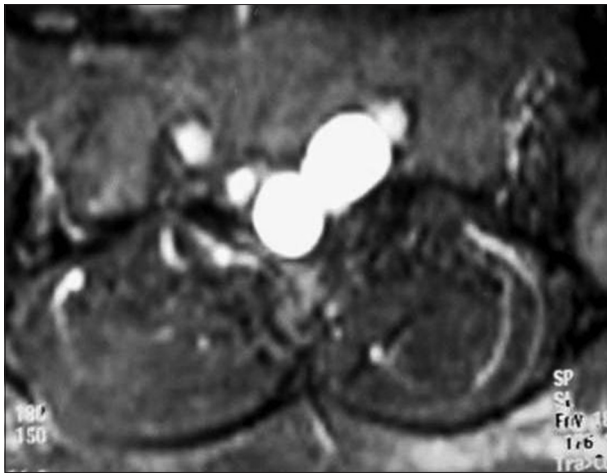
Magnetic resonance imaging scan (T2 weighted sequence, axial view) of the lumbosacral spine showing a well-defined cystic lesion along the traversing left L5-S1 nerve root suggestive of perineural cyst
